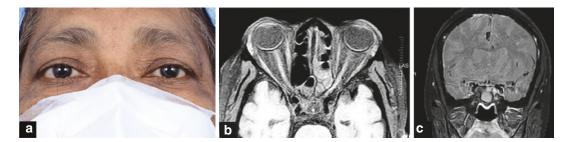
Stage 4b ROCM (a) Clinical picture showing no significant ocular manifestation, however, (b) Axial MRI (T1) of the orbit, paranasal sinuses and brain showed diffuse paranasal sinus involvement along with (c)
